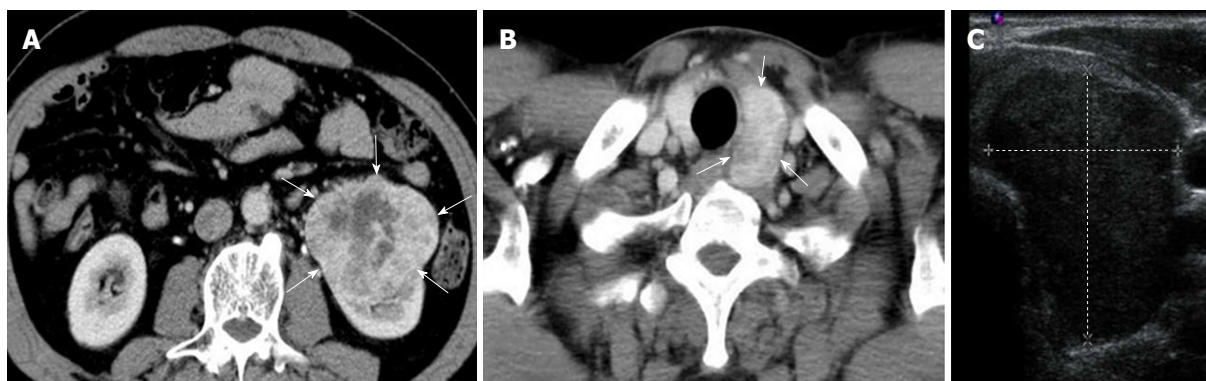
Initial radiological appearance of the kidney tumor and the thyroid left lobe mass. A: Preoperative contrast-enhanced computed tomography (CT) scan image of the left kidney tumor. The image shows a 6.0 cm × 5.0 cm exophytic mass in the lower pole of the left kidney (arrowheads). No lymphadenopathy was identified; B: Contrast-enhanced CT scan revealed a 4.0 cm × 2.5 cm solid mass with a smooth surface in the left lobe of the thyroid gland (arrowheads); C: The ultrasound imaging shows a 3.2 cm × 2.8 cm × 3.3 cm hypoechoic mass lesion without calcification in the left lobe of the thyroid.
